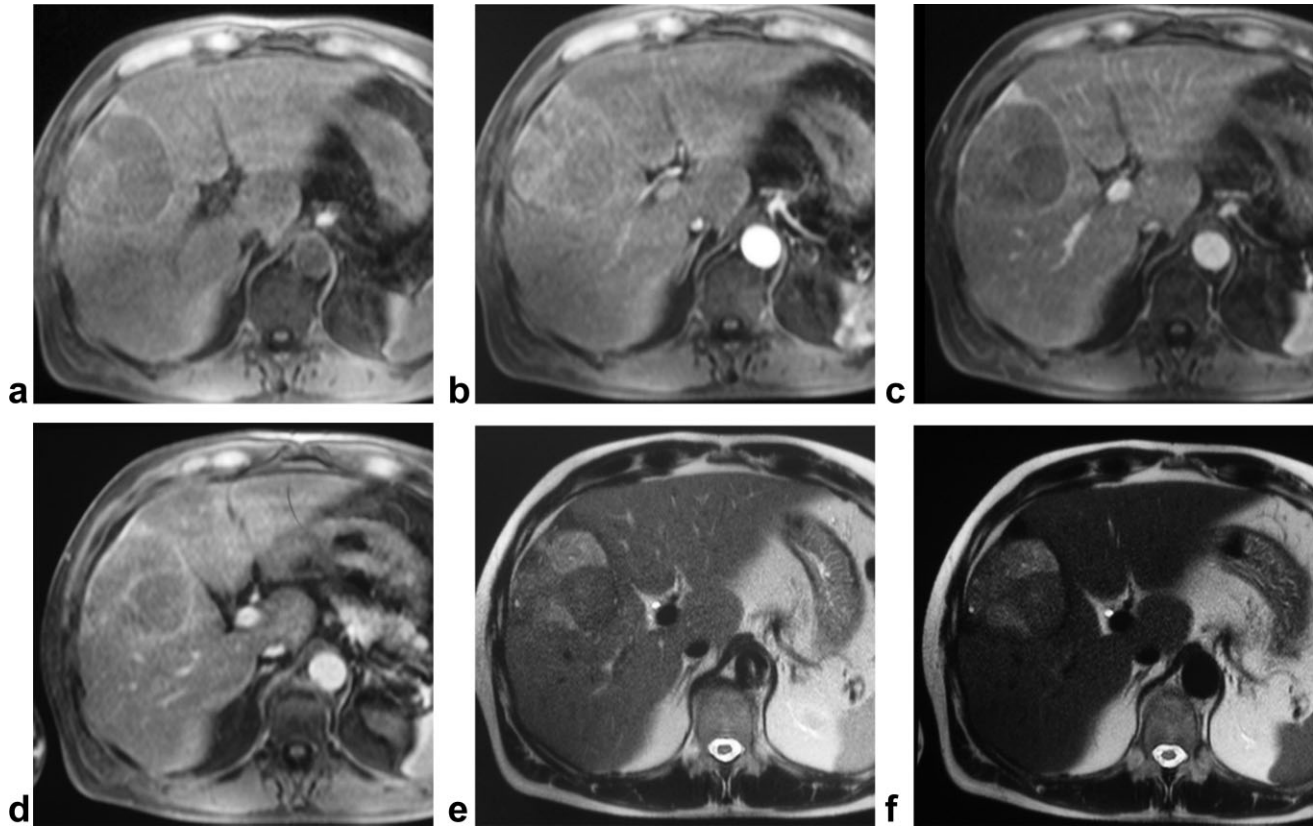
a-f: Hepatocellular carcinoma. Unenhanced T1-weighted VIBE acquisition (a) shows a round well-defined hypointense lesion in the V-VIII segment of the liver. After slow bolus Resovist administration, on the hepatic artery phase (b) a slight, heterogeneous enhancement can be detected, with subsequent washout phenomenon on the portal phase (c). At 10-min T1-weighted acquisition a peripheral ring of enhancement is appreciable (d). On the unenhanced HASTE T2-weighted sequence (e), the lesion appears heterogeneously hyper-iso-intense versus surrounding liver parenchyma without any signal intensity change, also at quantitative analysis, on the 10-min contrast-enhanced acquisition (f), where the nodule appears more hyperintense due to the signal loss of the remaining parenchyma.
